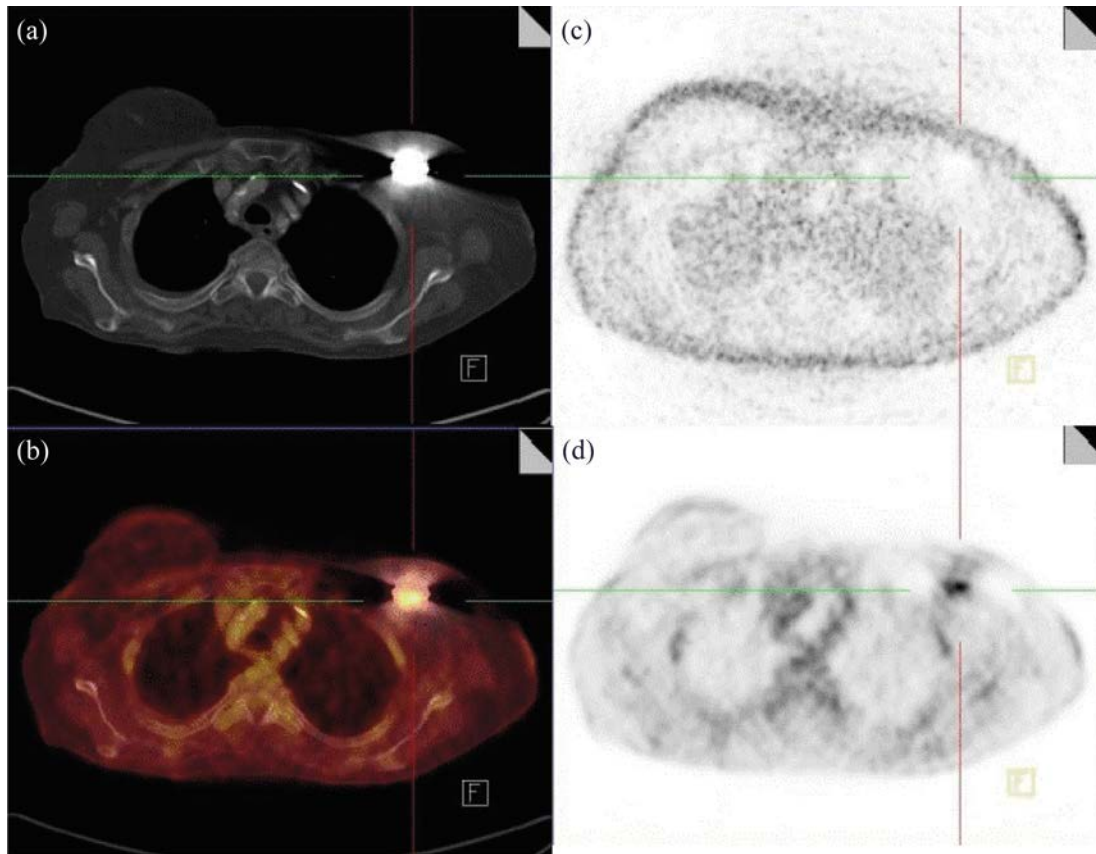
(a) CT scan shown in bone window; (b) fused AC-PET/CT, noAC-PET scan (c) and AC-PET (d) demonstrating artificially increased focal uptake in the area of the pacemaker. AC: attenuation corrected; noAC: not attenuation corrected.
